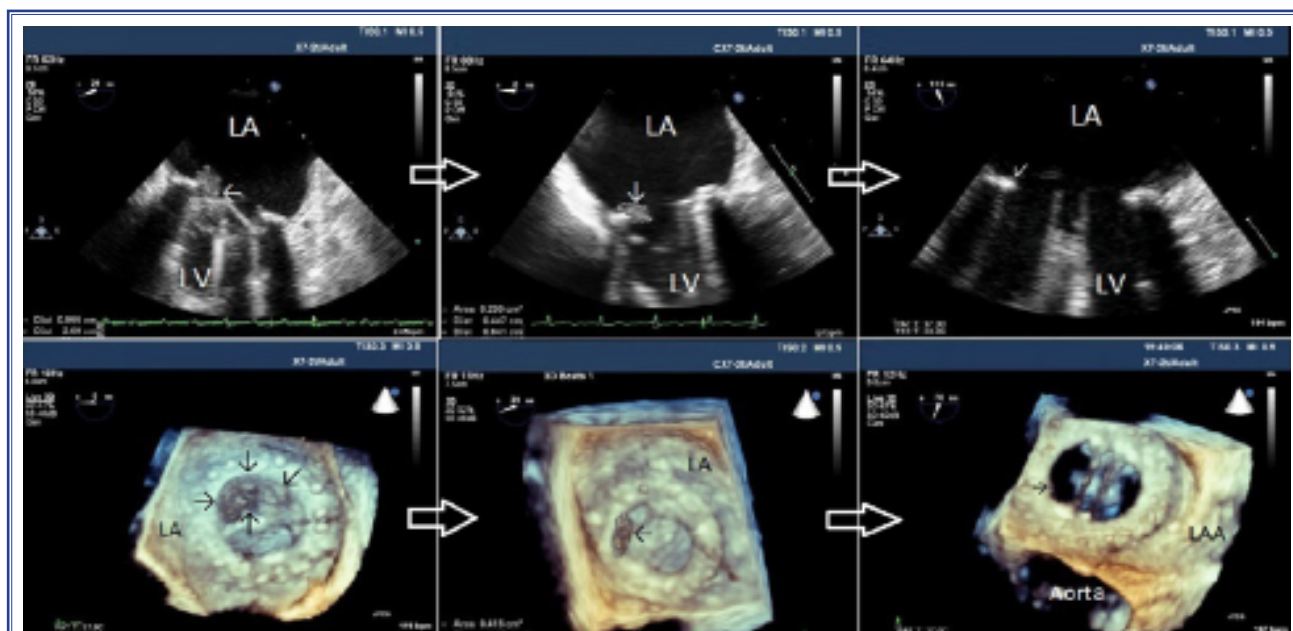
Serial 2-dimensional and real-time 3-dimensional transesophageal echocardiography images of obstructive prosthetic mitral valve thrombosis that was successfully treated with a low-dose ultra-slow infusion of tissue-type plasminogen activator. After 2 sessions of thrombolytic therapy, the thrombus burden was remarkably reduced. LA: Left atrium; LAA: Left atrium appendage; LV: Left ventricle.
